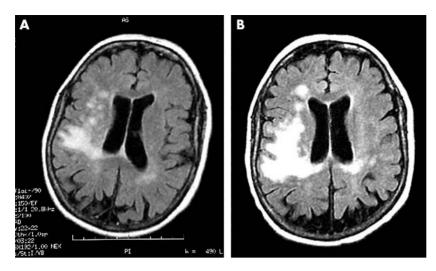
Magnetic resonance imaging of the brain. (A) 7 days and (B) 19 days after the initial symptoms in an immunocompromised patient with dermatomyositis and progressive multifocal leucoencephalopathy.
